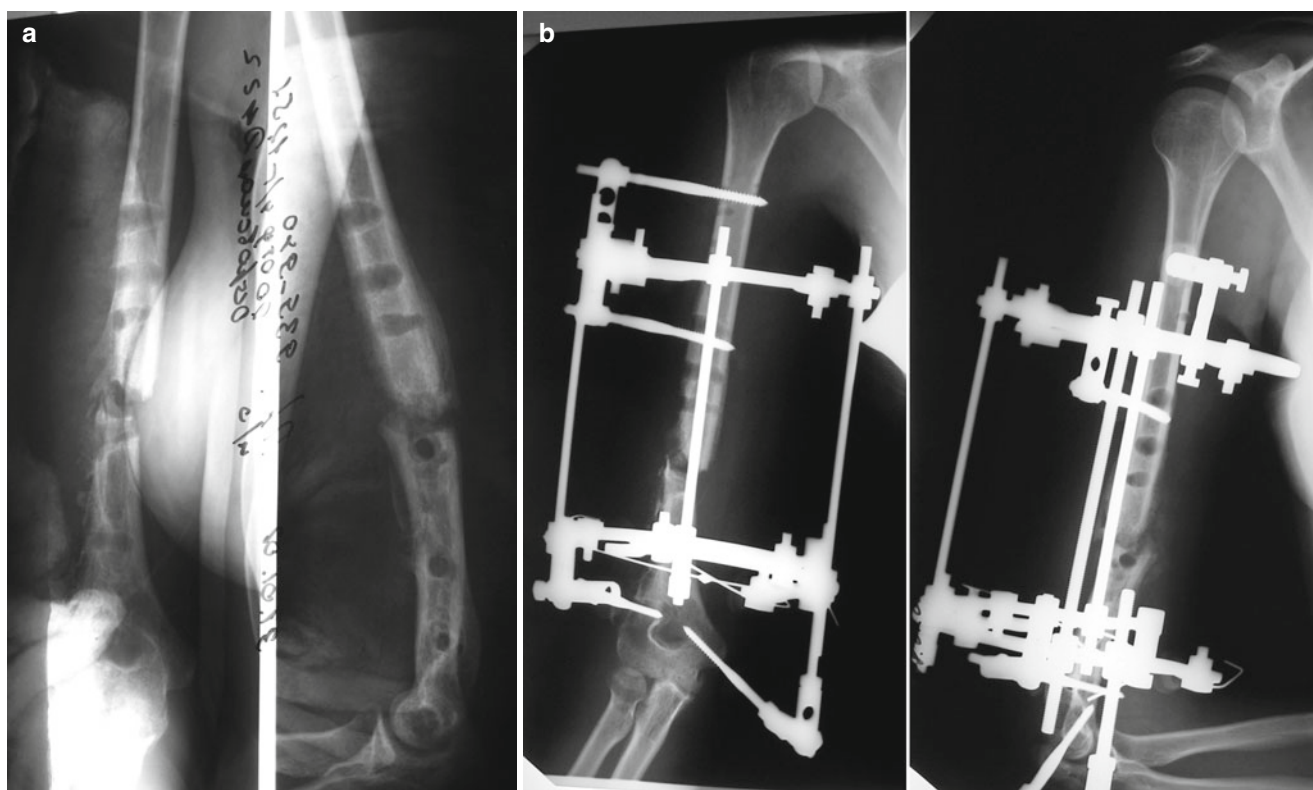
Treatment of a patient with a non-union of the humerus and pin-hole fracture. (a) Roentgenogram before treatment; (b, c) combined external fixation and upper limb function on postoperative day 4. (d) A fall from a height of 2 m resulted in a crisis in the field of half-pin
